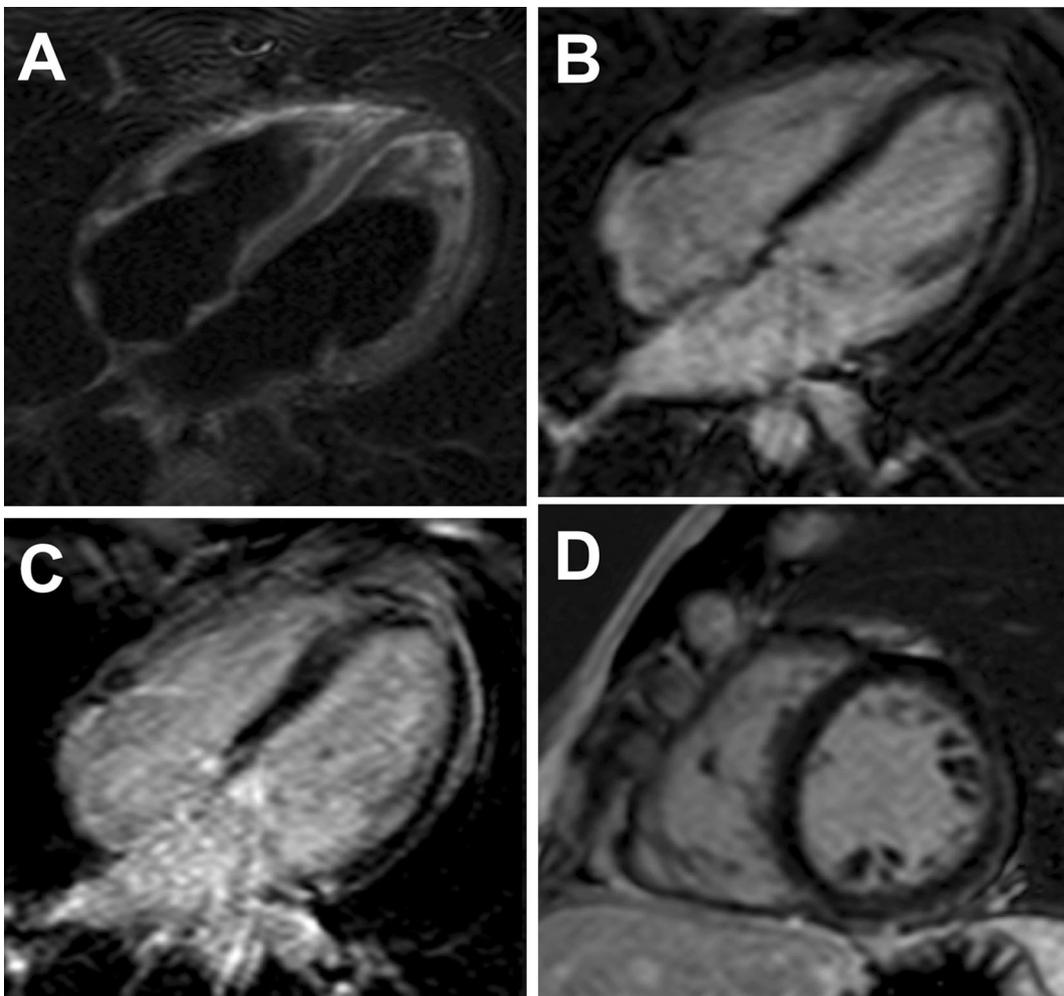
Acute myocarditis in a 42-year-old man presenting with fever, acute chest pain, and elevation of cardiac biomarkers. T2-weighted STIR images acquired in the four-chamber horizontal long-axis demonstrate myocardial edema in LV free wall (A). The typical pattern of sub-epicardial enhancement is shown on the corresponding four-chamber early gadolinium-enhancement sequences (B) as well as on the four-chamber and short-axis late gadolinium-enhancement sequences (C and D).
